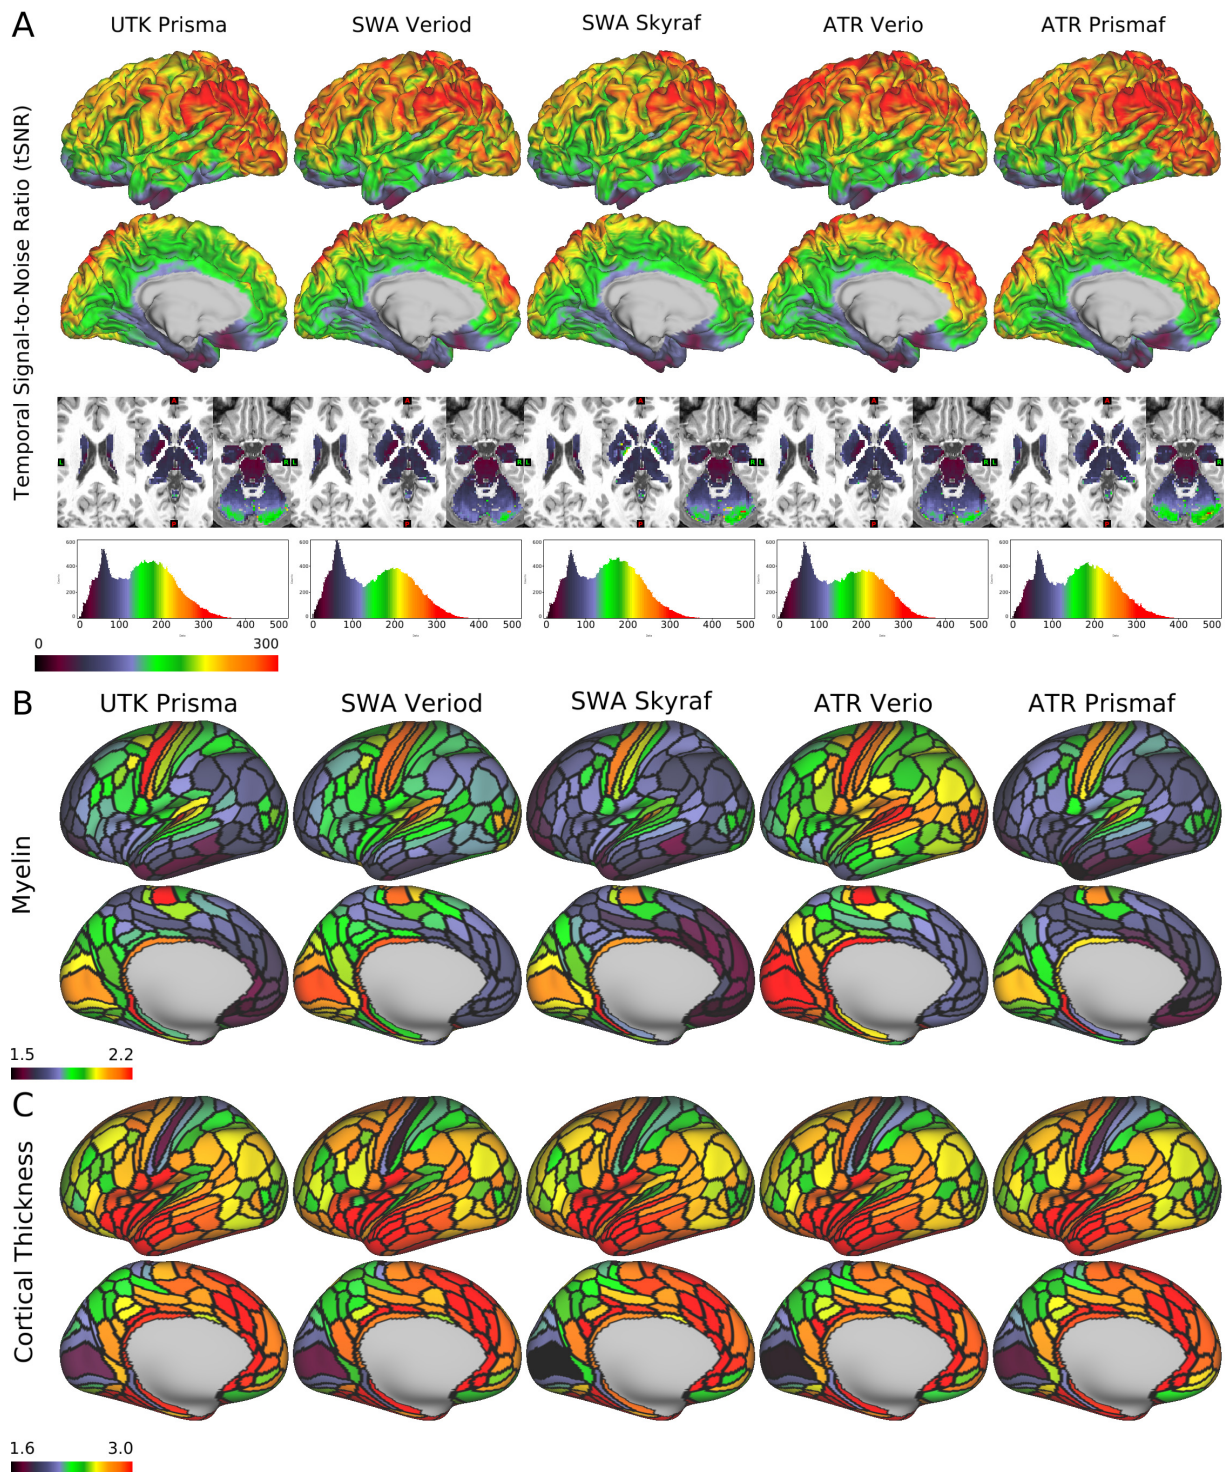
Quality of MRI and preliminary cortical structures obtained by HARP in a single traveling subject across scanners/sites.
